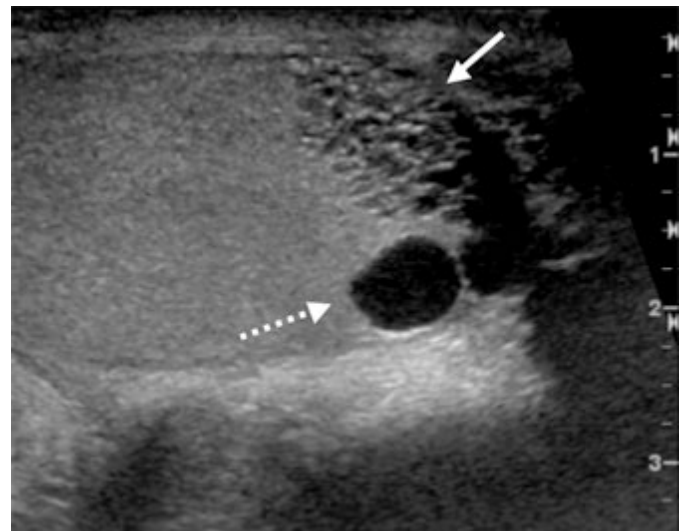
Ultrasound of the scrotum. Sagittal image of the left testicle demonstrates ectasia of the rete testes (solid arrow) with intratesticular cysts (dashed arrow). This finding, in association with azoospermia, is suggestive of an obstructive etiology and is helpful in directing further work-up in the setting of infertility.
